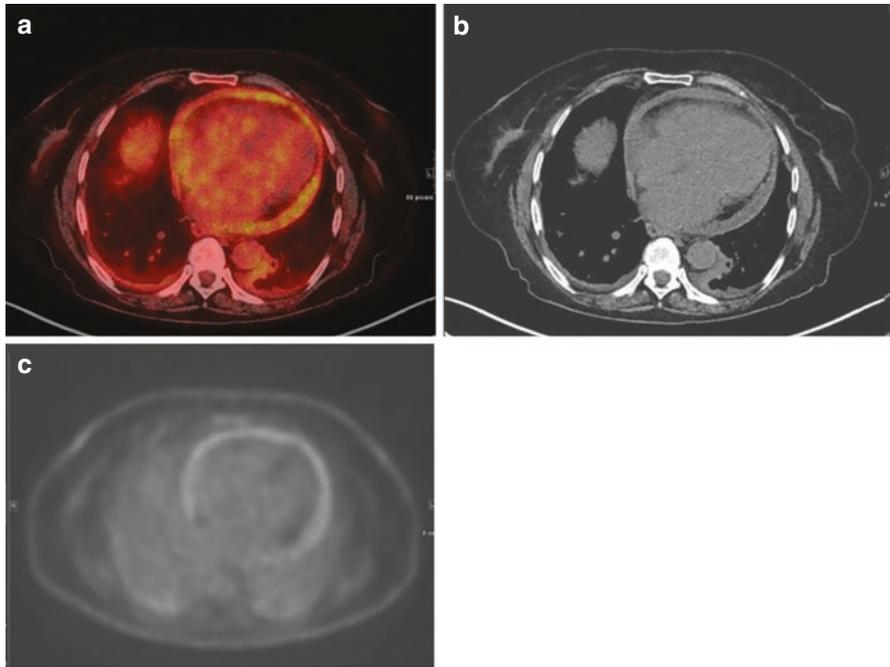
Representative images of a 78 year-old woman diagnosed with pericarditis. Patient underwent a 72h dietary preparation prior to the investigation in order to suppress the physiological myocardial glucose metabolism. Fused PET/CT images (a) show a diffuse, moderately increased FDG uptake within the pericardium, corresponding to a moderate pericardial effusion as seen on CT images (b). The extent of the hypermetabolism, consistent with an infective pericarditis, is more evident on PET images (c), wherein the absence of myocardial uptake can be demonstrated, which can rule out a concomitant myocarditis
